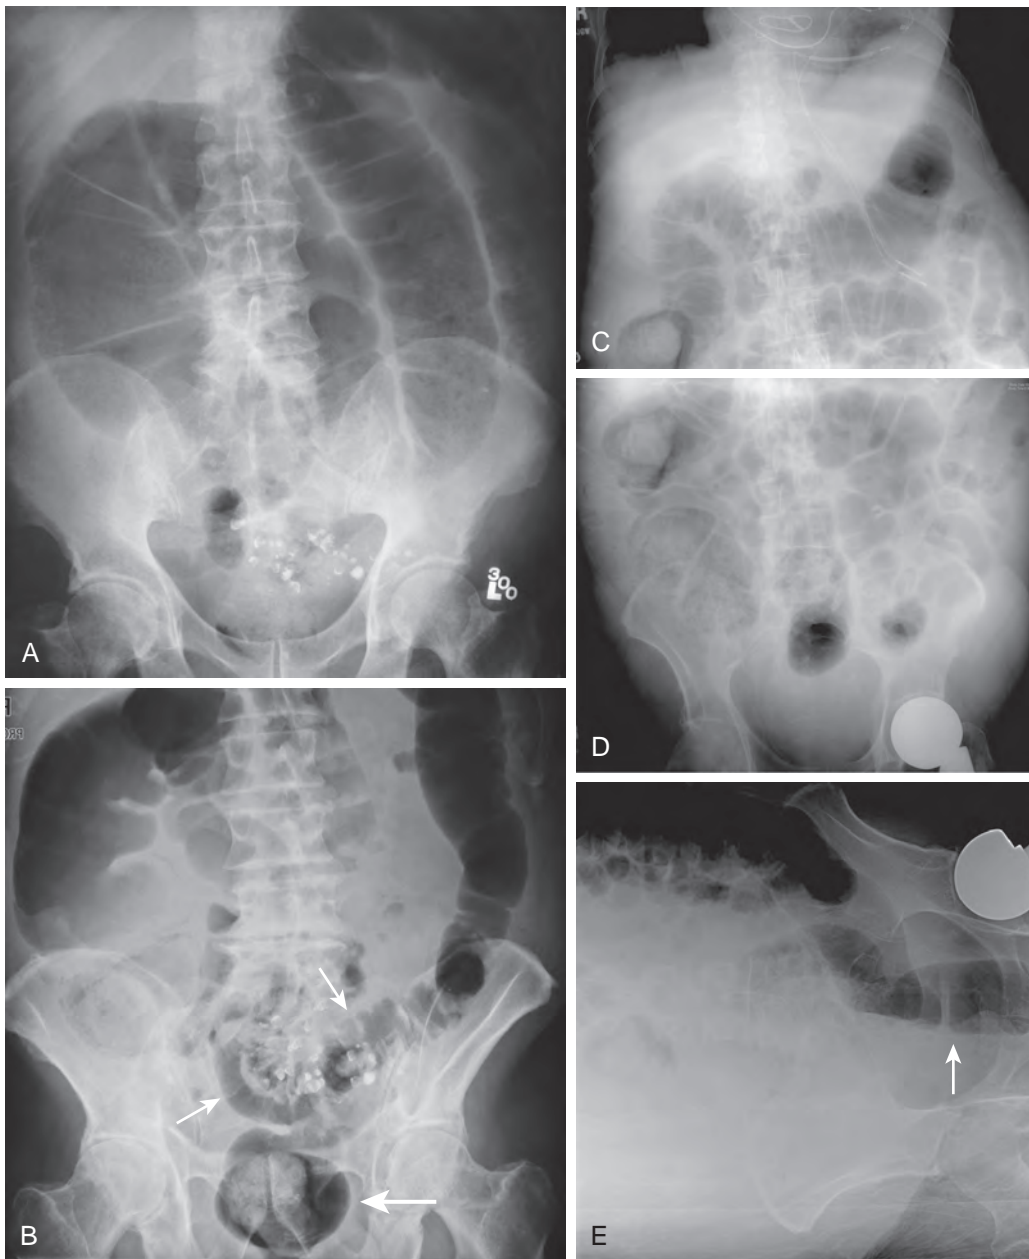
Value of prone and right lateral decubitus abdominal radiographs in patients with suspected colonic obstruction. A. Supine abdominal radiograph shows dilated colon to the level of the sigmoid with some stool but a paucity of gas in the rectum. Note residual barium in sigmoid diverticula. B. Prone abdominal radiograph in the same patient as in A shows gas in the sigmoid colon (small arrows) and rectum (large arrow), confirming that the patient does not have a distal colonic obstruction. C, D. Supine abdominal radiographs in another patient with abdominal distention show marked colonic dilation, with a paucity of gas in the rectum. E. Right lateral decubitus radiograph in the same patient as in C and D shows gas in the rectum (arrow), confirming that the patient does not have a distal colonic obstruction.
